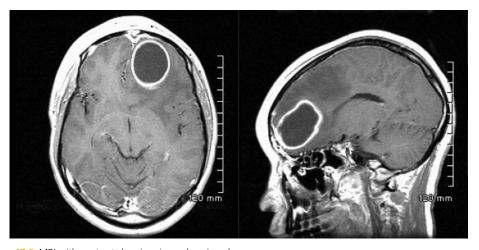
MRI with contrast showing ring enhancing abscess.
